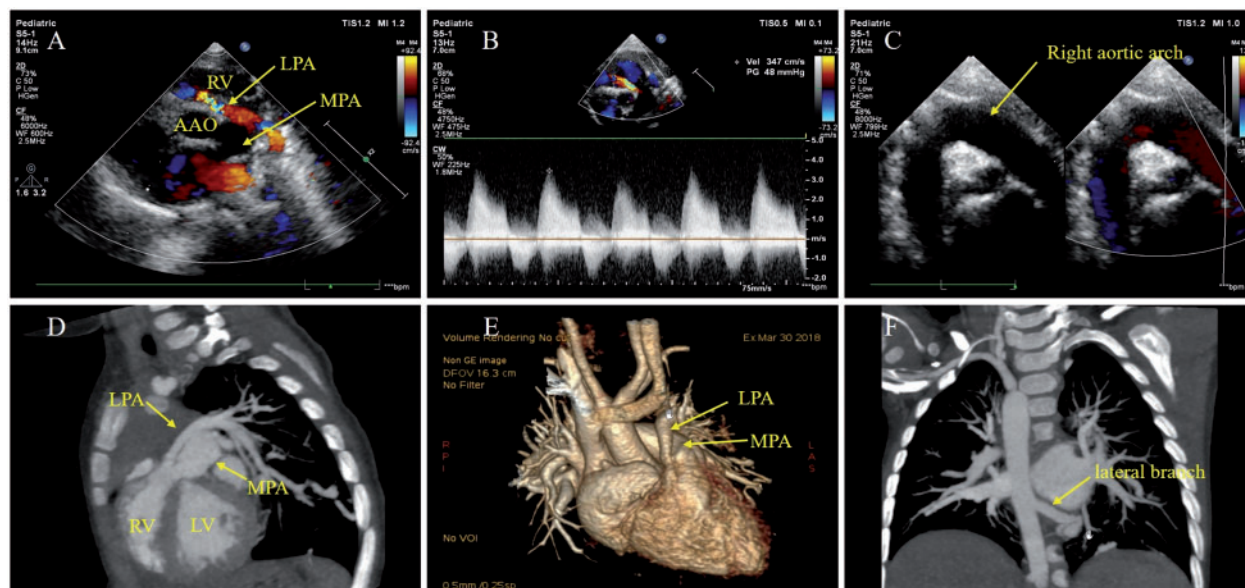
Anomalous origin of the left pulmonary artery from the right ventricle diagnosed by transthoracic echocardiography and multidetector computed tomography. (A) Transthoracic echocardiography showed a blood vessel arising from the right side of main pulmonary artery and then across main pulmonary artery to the left pulmonary hilum. (B) Biphasic blood flow in this vessel was observed by transthoracic echocardiography. (C) Right aortic arch was observed by transthoracic echocardiography. (D and E) The left pulmonary artery arising from right ventricle with stenosis was demonstrated by multidetector computed tomography. (F) A large lateral branch arising from the descending aorta to supply the left lung blood by multidetector computed tomography. AAO, ascending aorta; LPA, left pulmonary artery; LV, left ventricle; MDCT, multidetector computed tomography; MPA, main pulmonary artery; RPA, right pulmonary artery; RV, right ventricle; TTE, transthoracic echocardiography.
